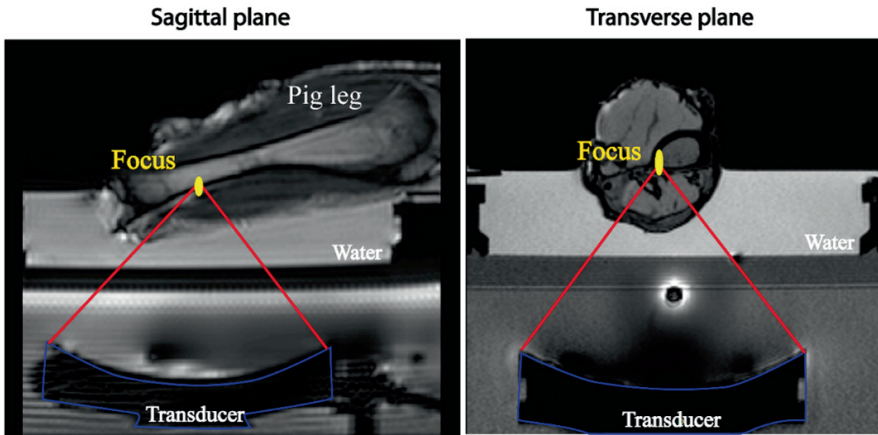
Experimental setup for the ex vivo experiment. The ultrasound transducer is outlined in blue and the ultrasound beam path in red. The imaging slice was positioned to match the focal location (in yellow).
